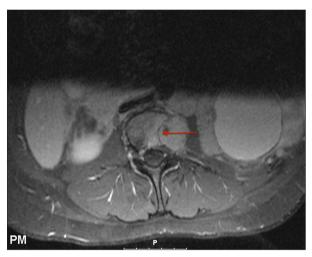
MRI of the lumbar spine showing osseous extension of primary tumor into left side of L3 vertebra.
